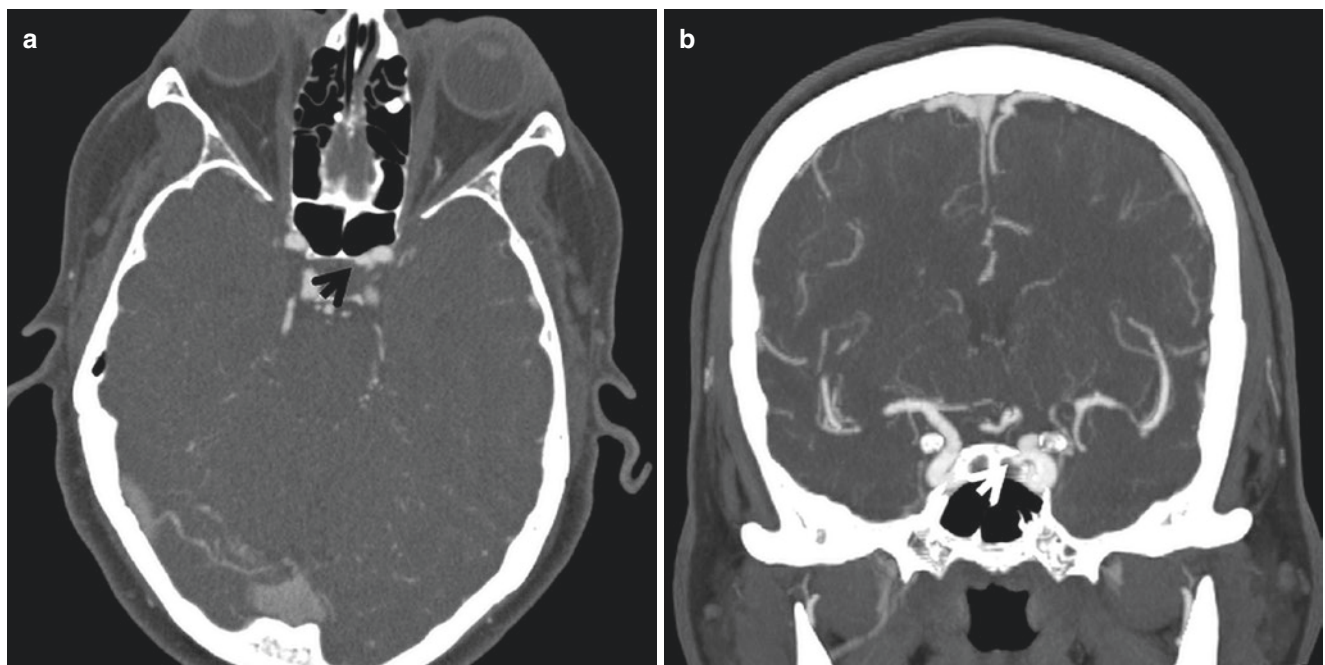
Superior hypophyseal artery aneurysm. Axial (a) and coronal (b) CTA demonstrates an aneurysm from the para-ophthalmic left ICA projecting medially to the sella, consistent with a superior hypophyseal artery aneurysm
